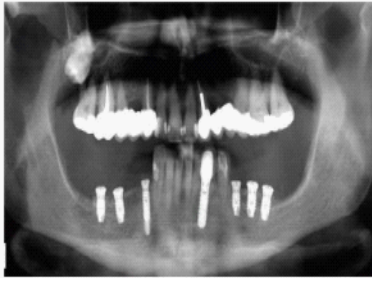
CT scan after implants insertion.
